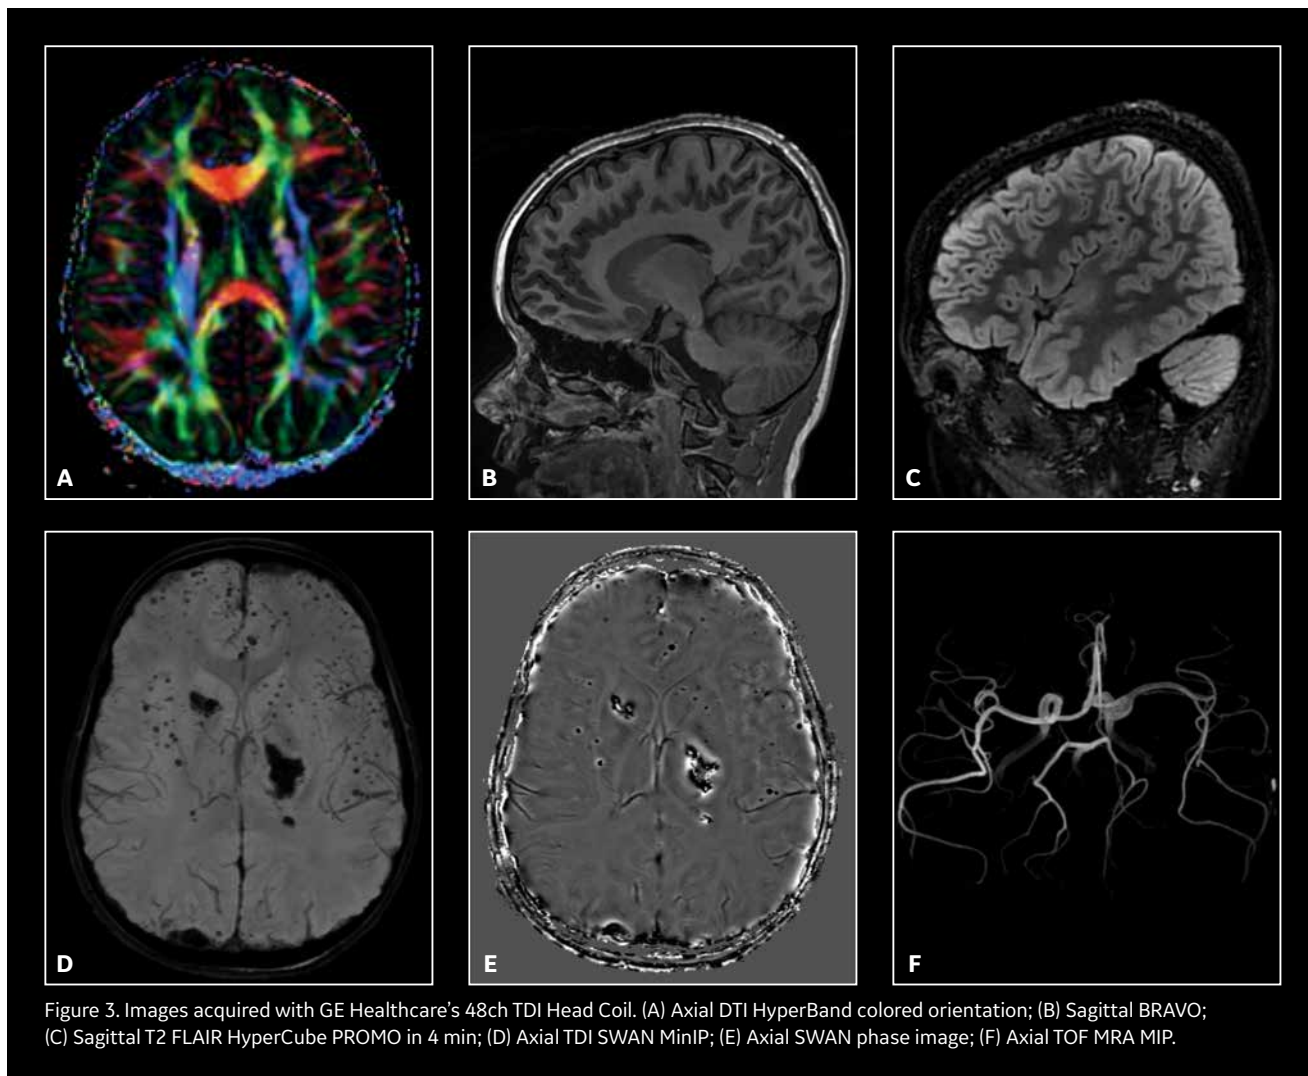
Images acquired with GE Healthcare's 48ch TDI Head Coil. (A) Axial DTI HyperBand colored orientation; (B) Sagittal BRAVO; (C) Sagittal T2 FLAIR HyperCube PROMO in 4 min; (D) Axial TDI SWAN MinIP; (E) Axial SWAN phase image; (F) Axial TOF MRA MIP.
